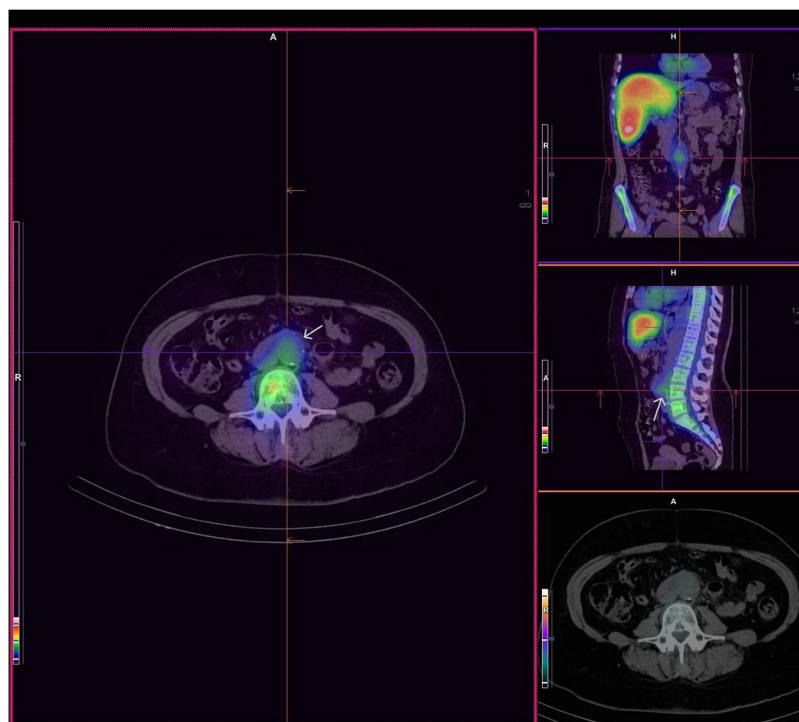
Single photon emission tomography/computed tomography with indium-111-oxine-labeled leukocytes at 24 hours postinjection. Pathological leukocyte accumulation in the posteromedial infrarenal aorta at the level of the L4 lumbar vertebra (arrow).
